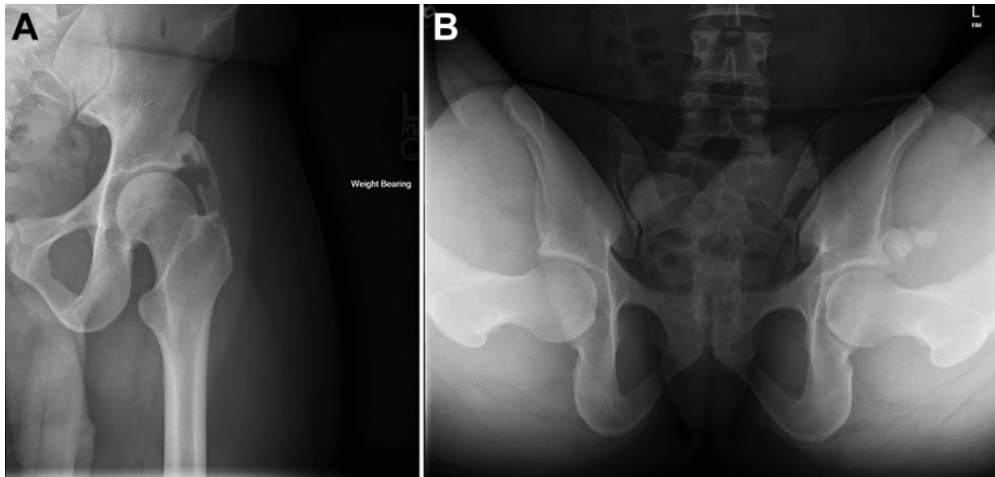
(A) Anteroposterior radiograph of a patient with heterotopic ossification of the left hip. Apparent bridging ankylosis is visualized. (B) A 90° Dunn view of the same patient demonstrating that the lesion is anterior to the femoral neck, without evidence of ankylosis.
